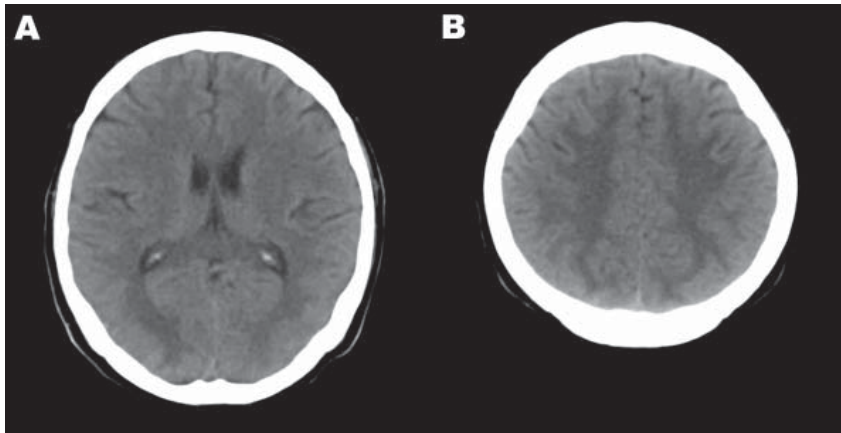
Computed tomography images of the brain of an adult patient with pandemic (H1N1) 2009 virus infection and neurologic signs. A noncontrast study showed hypodense lesions in both occipital lobes (A) and in both upper parietal lobes (B).
